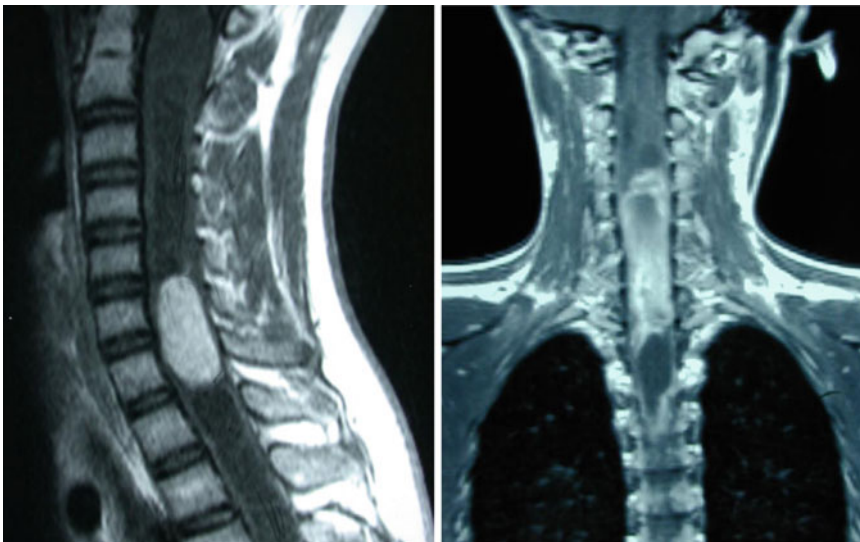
T1-weighted MRI of cervical spinal cord ganglioglioma, sagittal (*left*) and coronal (*right*) views: Although spinal cord gangliogliomas have been reported
